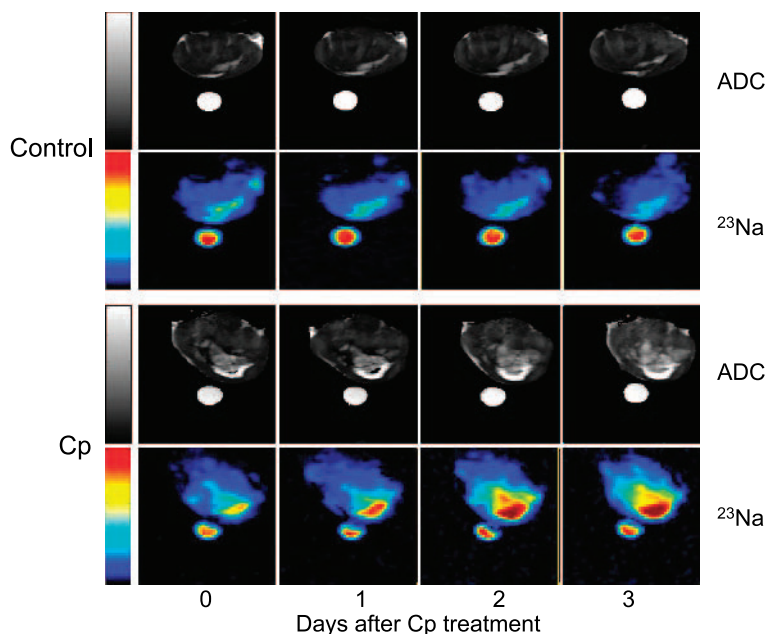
Water ADC maps and ²³Na MR images of representative control and Cp-treated RIF-1 tumors before and 1, 2, and 3 days after Cp treatment. Water ADC and ²³Na signal intensity increased with time after Cp treatment. A vial filled with a 154-mM NaCl solution was placed near the tumor as a reference.
